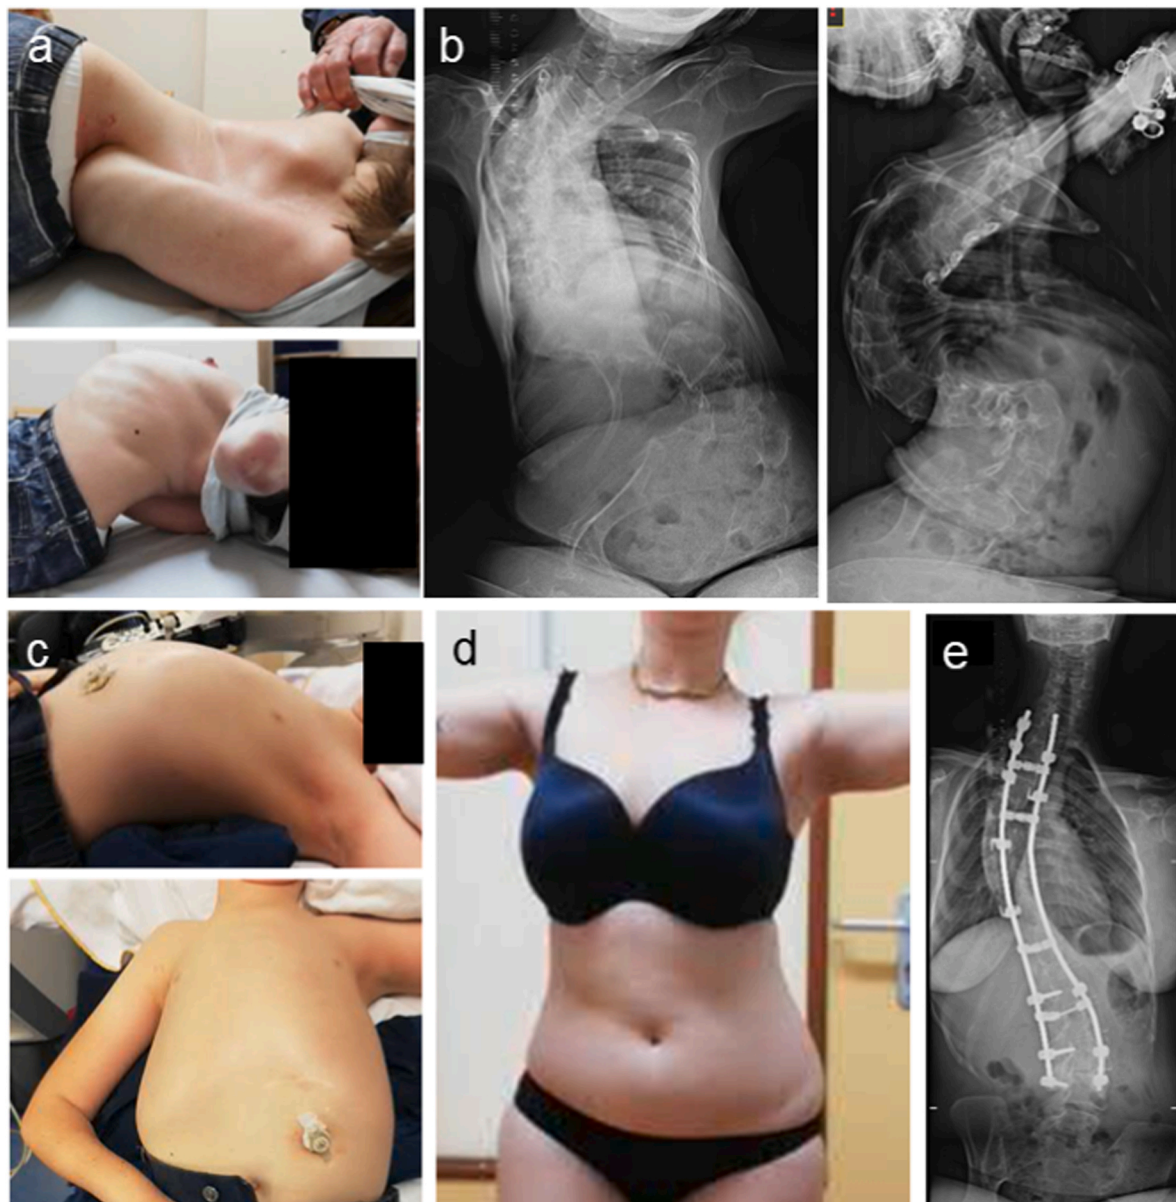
Thorax deformities in LAMA2-MD and SELENON-RM patients. (a) severe thorax deformity in a LAMA2-MD patient, showing an asymmetric protrusion of the anterior chest wall, an asymmetric retropulsion of the posterior chest wall, a rotation component of the chest wall and scoliosis. (b) X-ray of the spine and thorax of patient shown in a, showing a severe kyphoscoliotic spine with a Cobb's angle of 130° between C7 and L2 and a Cobb's angle of 100° between L2/L3. (c) severe thorax deformities showing pectus carinatum. (d) SELENON-RM patient, showing from the outside only subtle thorax deformities. (e) X-ray of patient shown in d showing evident thorax deformities secondary to scoliosis.
